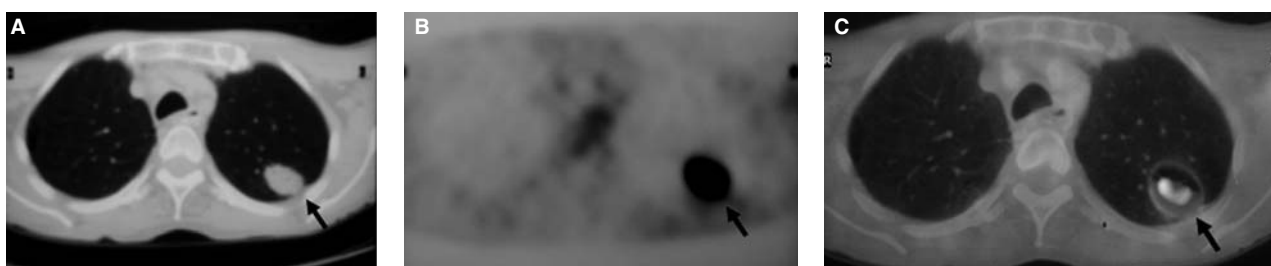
Malignant solitary pulmonary nodule visible with increased definition in the study performed simultaneously with positron emission tomography and chest computed tomography (thoracic PET-CT) and that was subsequently identified as a pulmonary adenocarcinoma. The nodule is shown in the chest CT (A), PET (B), and PET-CT (C). The arrows indicate the site of the malignant nodule.
